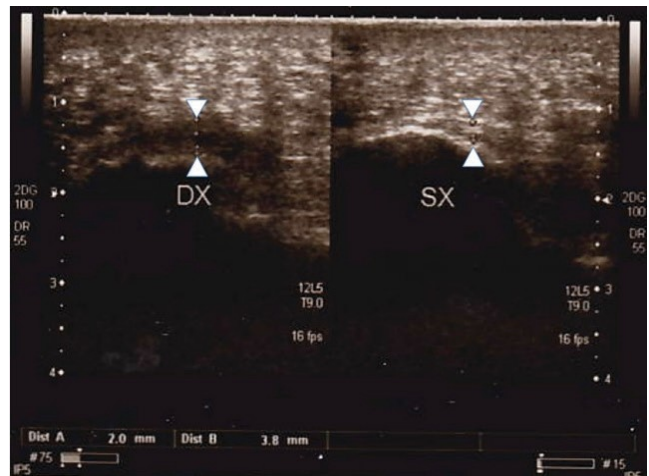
Pretreatment ultrasound scan, clinical case 2: Thickening and enhanced hypoechoogenicity of the calcaneal insertion of the plantar fascia consistent with fasciitis.
